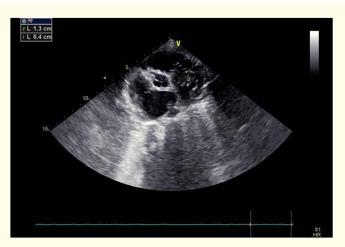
Parasternal short-axis view of the dilated right coronary artery. Movie clip S1: Multiple regions of color turbulence in the ventricular septum due to flow within coronary collaterals.
